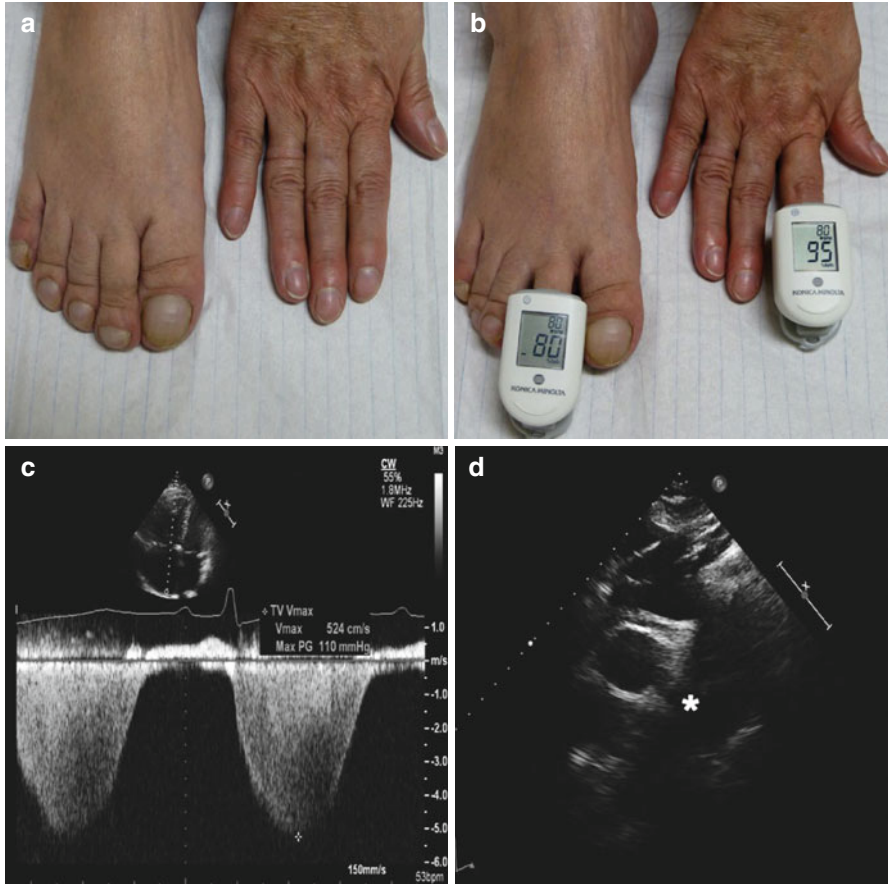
(a–d) 52-year-old woman was seen at the outpatient clinic for adults with congenital heart disease. Cardiac auscultation revealed a single and loud S2 and a soft pansystolic murmur of tricuspid regurgitation. On clinical examination, clubbing of the toes was noted and cyanosis was present only in the lower half of the body, whereas her fingers did not present evidence of clubbing or cyanosis (a). Using the same pulse oxymeter model simultaneously at her fingers and her toes while breathing room air, differential cyanosis (SO₂ toes 80%, SO₂ fingers 95%) could be confirmed (b). On 10 L O₂ via nasal cannula SO₂ on the lower extremities remained unchanged, whereas SO₂ increased in the upper extremities. Echocardiographically, a suprasystemic right ventricular systolic pressure was measured (estimated systolic pulmonary arterial pressure 120 mmHg) with an arm-cuff blood pressure measurement of 115/83 mmHg (c). As clinically suspected, a large patent ductus arteriosus (PDA) was found (marked with *asterisk* in d) (Used with permission from Moccetti et al. [17])
